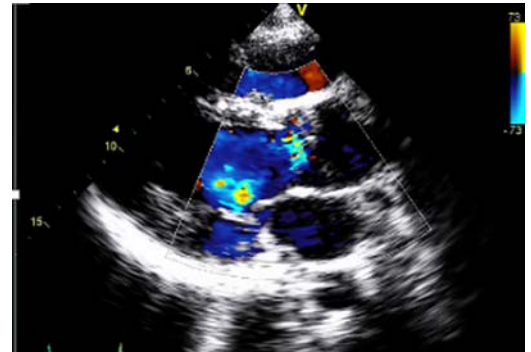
Colour Doppler echocardiography showing aortic regurgitation.
